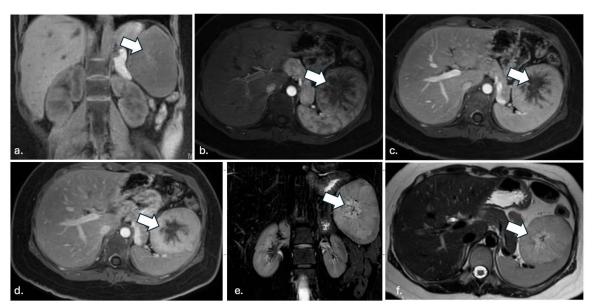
18-year-old female with splenic lymphangioma. MRI Abdomen showed a well-defined focal mass (arrows) at the anterior spleen measuring 8.1 x 6.4 x 9.0 cm, with progressive peripheral enhancement through delayed imaging with a central non-enhancing stellate component, likely reflecting fibrotic changes. (A) MRI abdomen T1 late arterial phase postcontrast, coronal view; (B) T1 late arterial phase postcontrast, axial view (C) T1 venous phase postcontrast, axial view; (D) T1 5 minutes postcontrast, axial view; (E) T2, coronal view; (F) T2, axial view.
